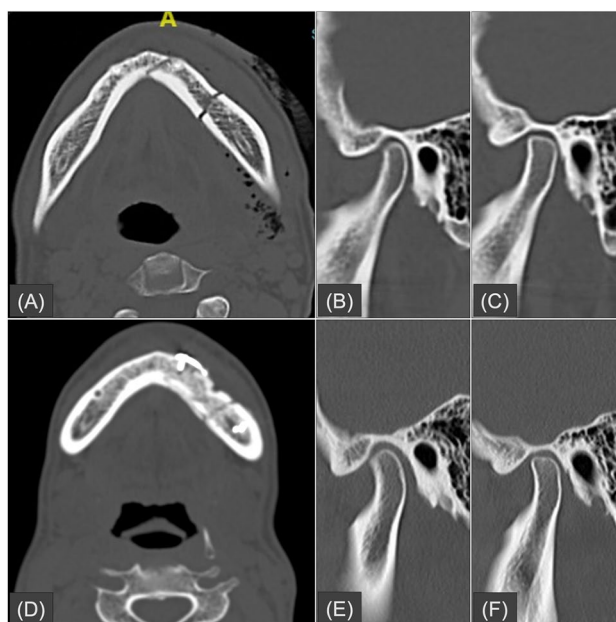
Initial CT images of a 38-year-old man showed mandibular symphysis and left body fracture in the axial plane (A). No fracture, dislocation, or pre-existing degeneration was noted in the right (B) and left (C) temporomandibular joints (TMJ) on sagittal reformation of the initial CT. The patient underwent surgical fixation for the mandible fracture (D). Follow-up CT images 9 months after the fracture showed no apparent degenerative changes in the right (E) and left (F) TMJ
